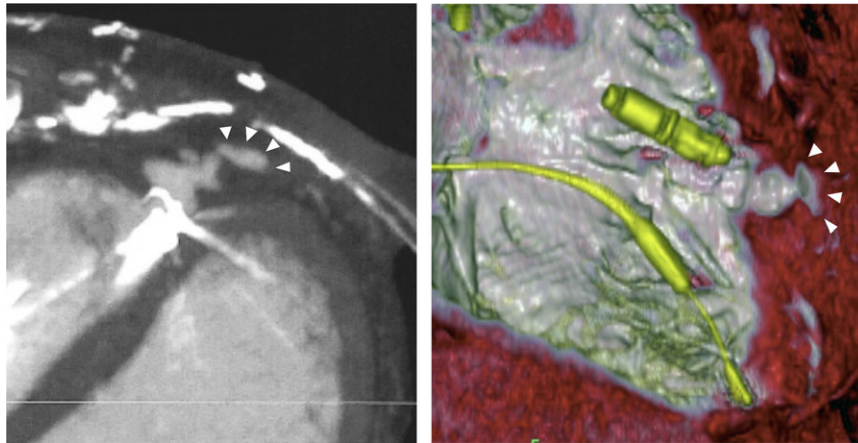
Images generated by cardiac computed tomography scan 3 d after the implant. A protruded diverticular structure was observed on the right ventricle. Arrowheads indicate that the contrast material remained inside a pouch within the pericardium
